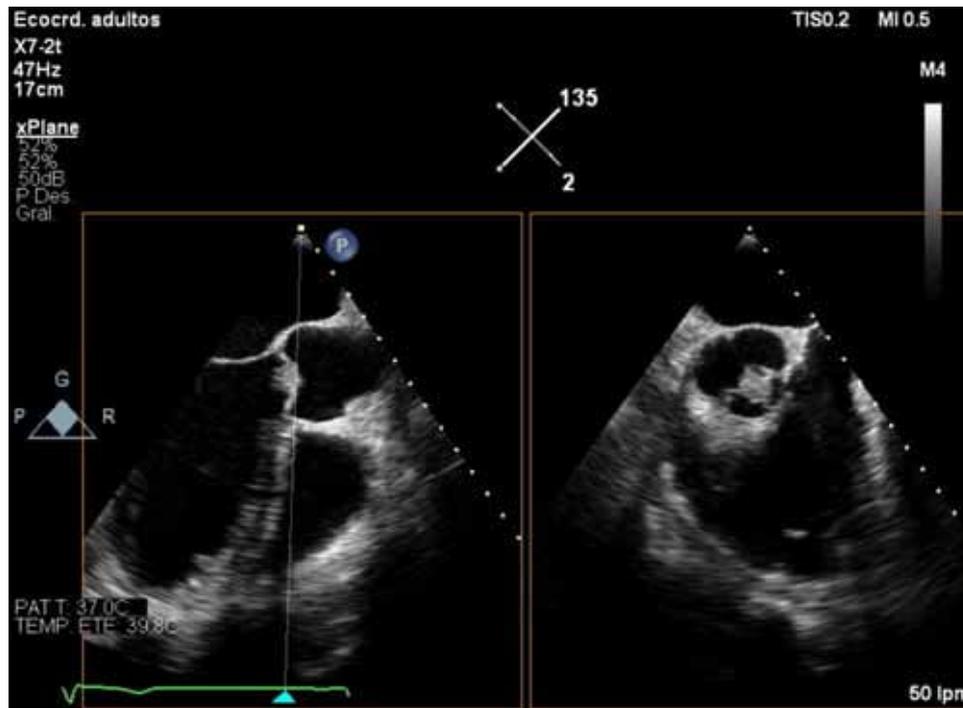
2 D transesophageal echocardiography image of the aortic valve with orthogonal planes to the long axis (135°) and short axis (45°).
